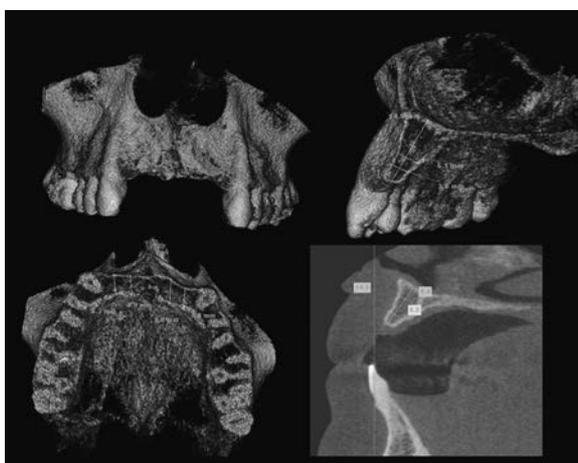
Alveolar height and width assessment for the placing of dental implants. The CBCT image gives a true 1:1 three dimensional representation of the patient.
